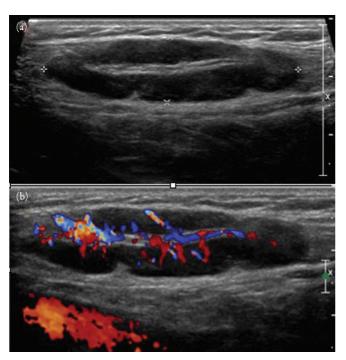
Lymph node. Grayscale and color Doppler sonographic images in longitudinal plane of the groin show a well-circumscribed subcutaneous soft tissue mass. The mass is mainly hypoechoic with a central vascular echogenic region. This is the typical sonographic appearance of a normal lymph node.
